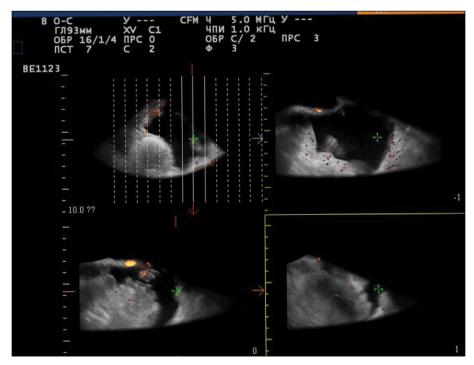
US-CT of the recurrent lesions of the malignant struma ovarii.
